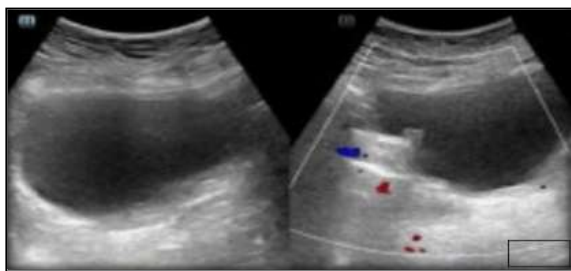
Ultrasound Color Doppler showing no evidence of uterus
